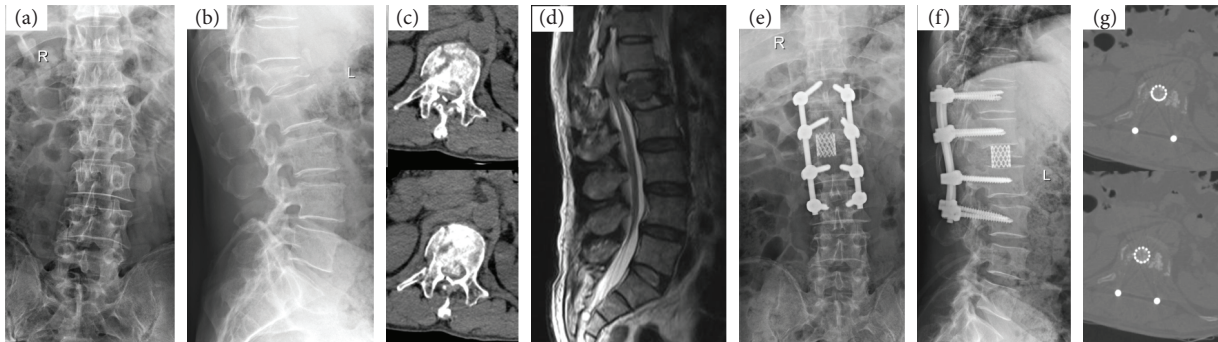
A 48-year-old male patient who was suffering from severe neurological deficit with a grade of ASIA A on admission. Preoperative X-ray (a, b) show L1 fracture with Cobb angle 19° , CT (c) with severe spinal canal encroachment, MRI (d) showed that the spinal cord was not transection in the injury segment. Undergoing PIVCR and spinal shortening, patient achieved to correct segmental kyphosis deformity, restore vertebral body height (e, f), direct good decompression the neural elements (g) and neurological function improved to ASIA E.
